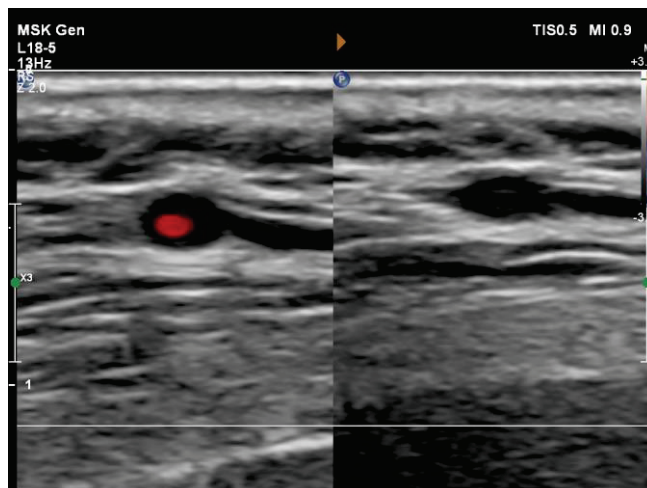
Detection of arterial inflammation by “compression sign”. Pressure applied with an ultrasound probe collapses the artery. The resulting restriction of blood flow is confirmed by the absence or limitation of a Doppler signal in the arterial lumen. However, the thickened inflamed arterial wall remains visible as a hypoechoic area contrasting with the mid-echogenic to hyperechoic surrounding tissue [5].
